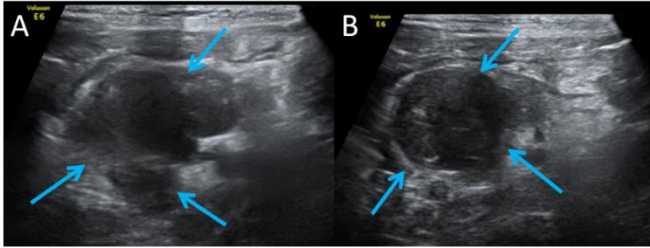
A and B; para umbilical abdominal ultrasound revealing multiple enlarged and hypoechoic lymph nodes.
